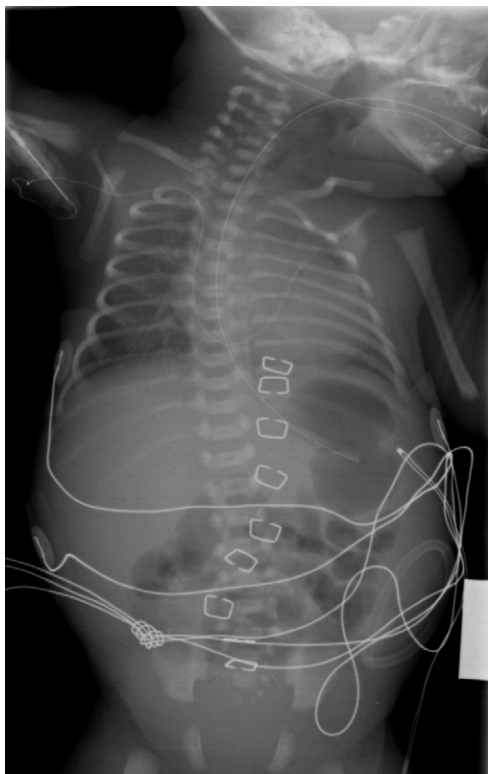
High anorectal agenesis. Plain radiograph shows absence of rectal air shadow. (Courtesy of Raj Paspulati, M.D.)
